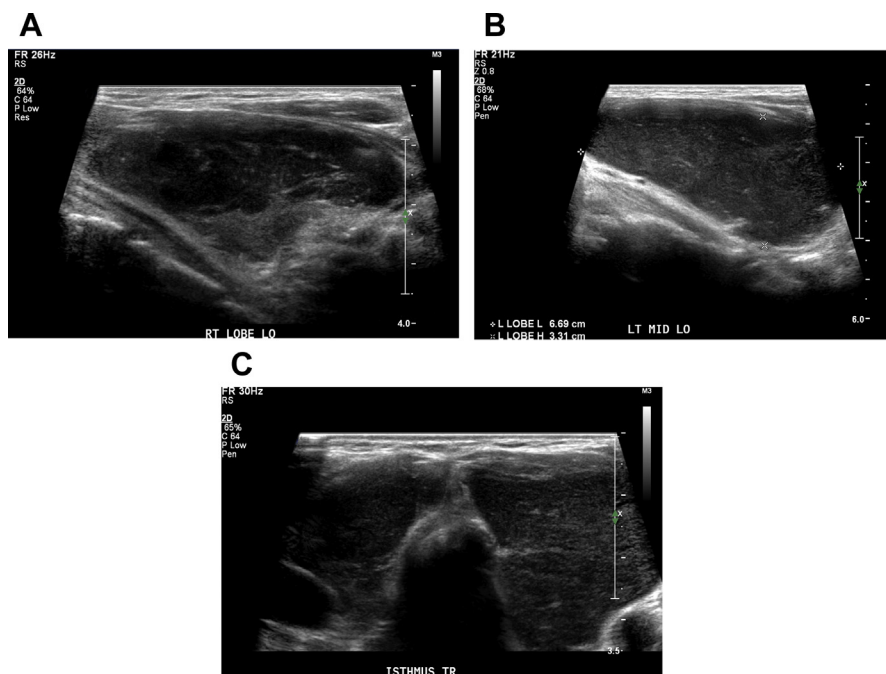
An 84-year-old woman with large B-cell lymphoma on gray-scale ultrasound of the thyroid. (A–C) Thyroid gland is enlarged with near-complete replacement of gland with hypoechoic infiltrate in the right longitudinal (A), left longitudinal (B), and bilateral lobe transverse view (C). Biopsy showed large B-cell lymphoma. Cursors on (B) represent thyroid lobe measurement in the longitudinal plane.
